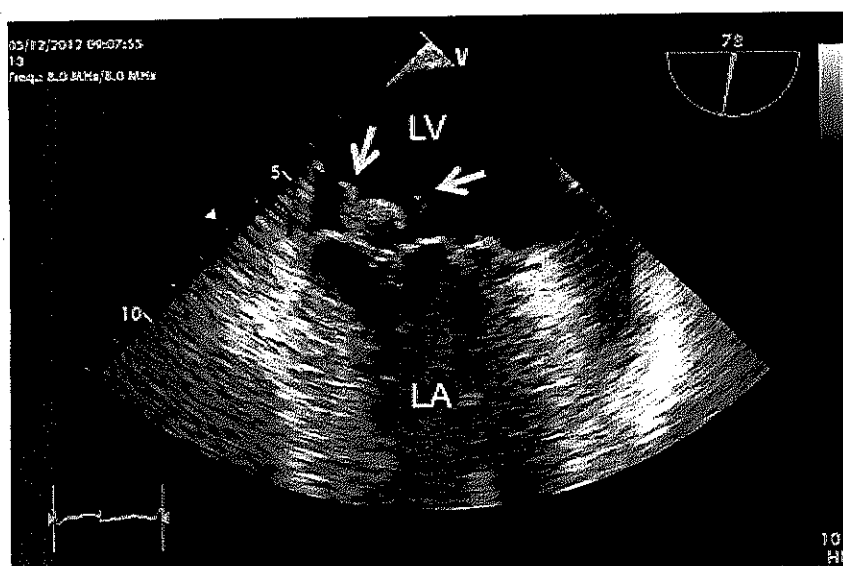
Myxomatous mitral valve with endocarditis. Transesophageal echocardiography views: posterior leaflet thickening with flail of the P2-segment (ruptured chordae tendineae) and vegetation on the atrial surface of the leaflet (arrows) in systole.
